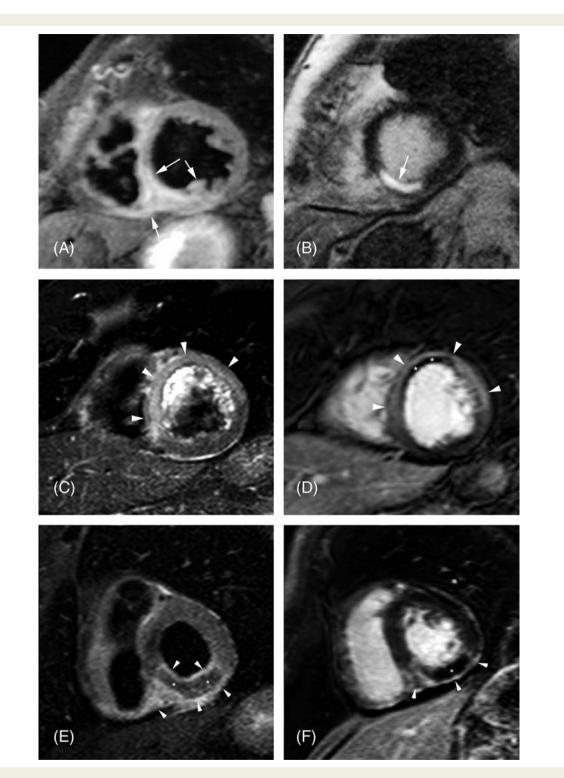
Short-axis T2-weighted (A, C and E) and contrast-enhanced (B, D and F) magnetic resonance images in three patients with acute myocardial infarction. Panels A and B show matched short-axis views of a patient with an inferoseptal myocardial infarction. High signal intensity on the inferoseptal myocardial segments extending to the inferior right ventricular wall corresponding to the area at risk with myocardial oedema can be seen in panel A (arrows). Almost transmural necrosis on the same myocardial segments without evidence of microvascular obstruction (panel B, arrows). Panels C and D show images from a patient with acute anteroseptal myocardial oedema is seen in panel C (arrow-heads). Early contrast-enhanced images show a hypointense area in the core of the infarct corresponding to microvascular obstruction (panel D, asterisks). Panels E and F show images from a patient with acute inferior myocardial infarction with myocardial haemorrhage and microvascular obstruction. Myocardial haemorrhage is visible as a central hypointense area (panel E, asterisks) within the area of myocardial oedema that extends into the right ventricle (panel E, arrowheads). Panel F shows a large area of transmural necrosis (arrowheads) with a large core of microvascular obstruction (asterisk).
